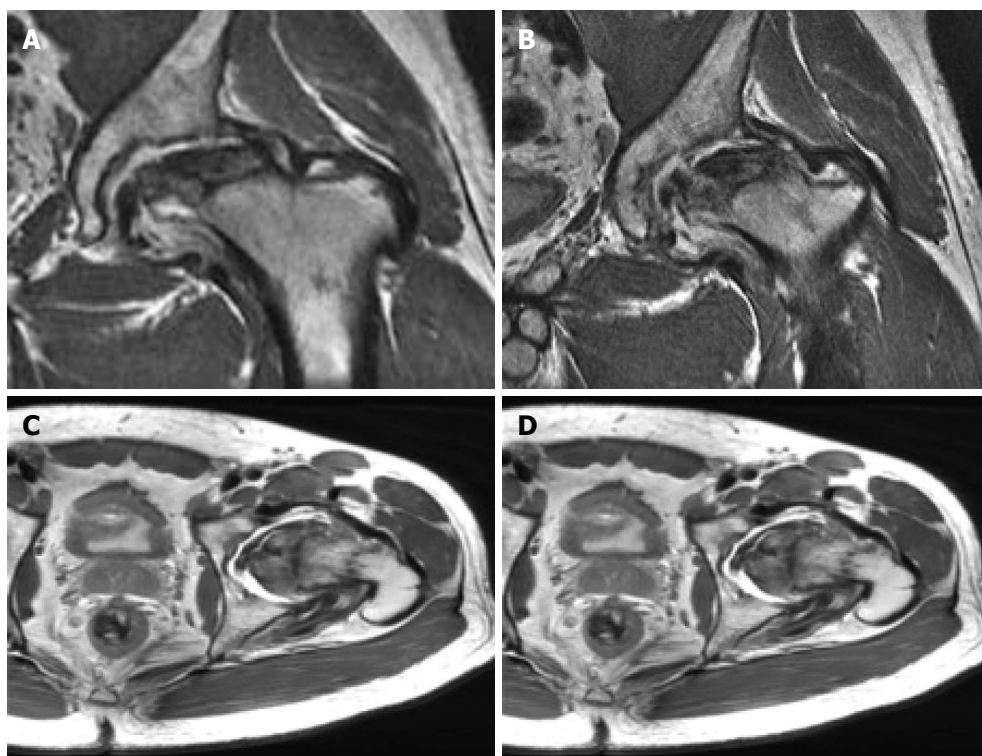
Magnetic resonance imaging of the left hip showing extensive avascular necrosis of the femoral head with collapse and a large area of devitalized bone demonstrating fibrocystic change. There is associated severe arthrosis of the left hip joint with a moderate effusion, synovitis and debris and a marked bone marrow edema pattern on both sides of the joint.
